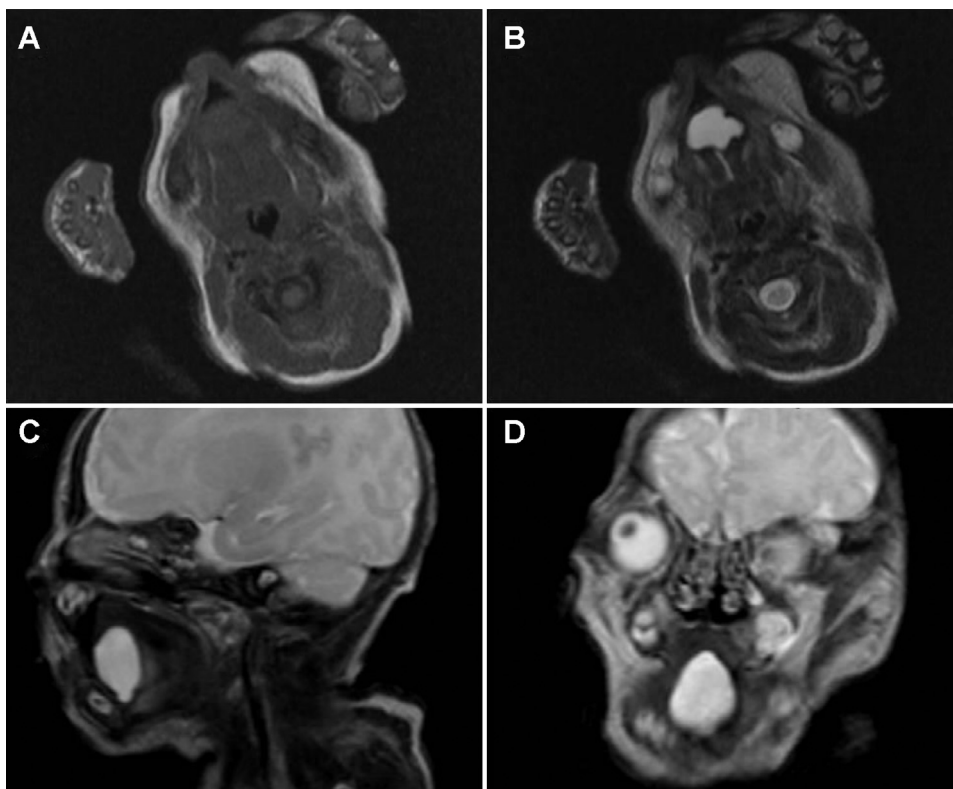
Magnetic resonance images. (A) Horizontal section, T1-weighted image. (B) Horizontal section, T2-weighted image. (C) Coronal section, T2-weighted image. (D) Sagittal section, T2-weighted image. The T1-weighted image demonstrates a low signal intensity, while the T2-weighted images demonstrate a high signal intensity. A well-defined mass with a maximum diameter of 25 mm is observed.
